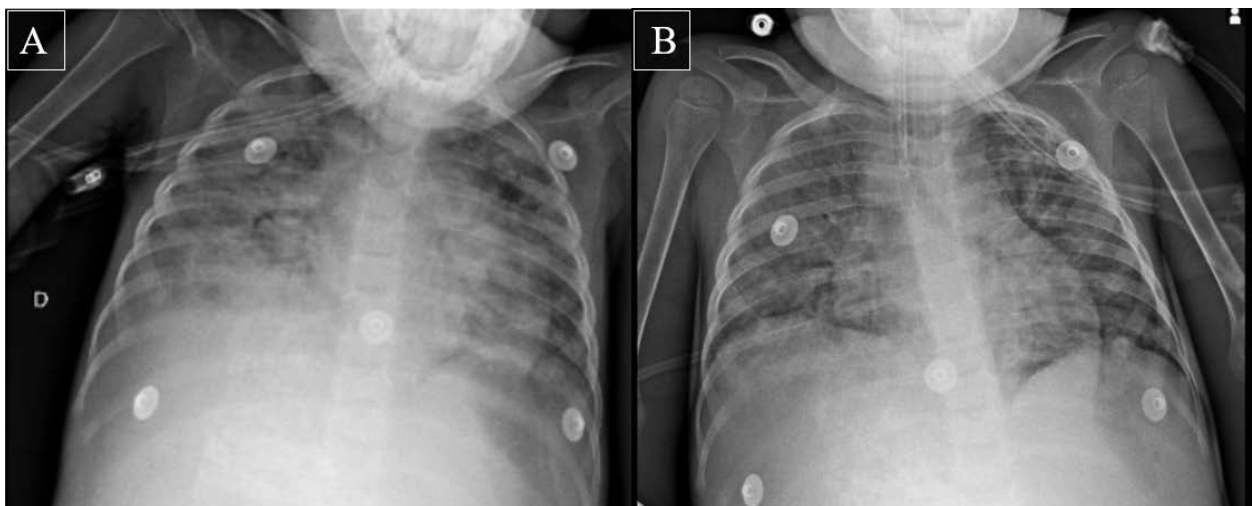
Chest radiographs showing tube position before replacement (A) and before/after replacement (B)
